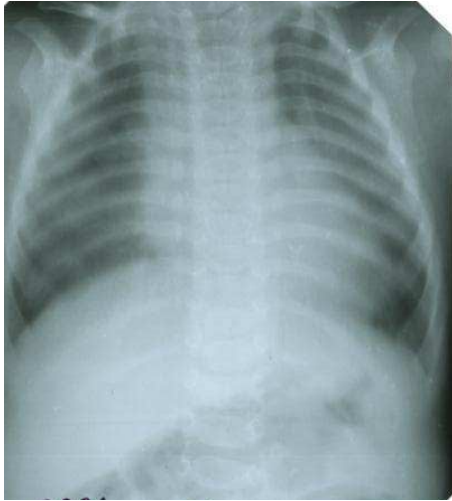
shows an X-ray image of the preparation of the newborn body obtained by the method of Microfocus X-ray radiography in unspecialized conditions on the X-ray diagnostic complex "PARDUS-Neo".
